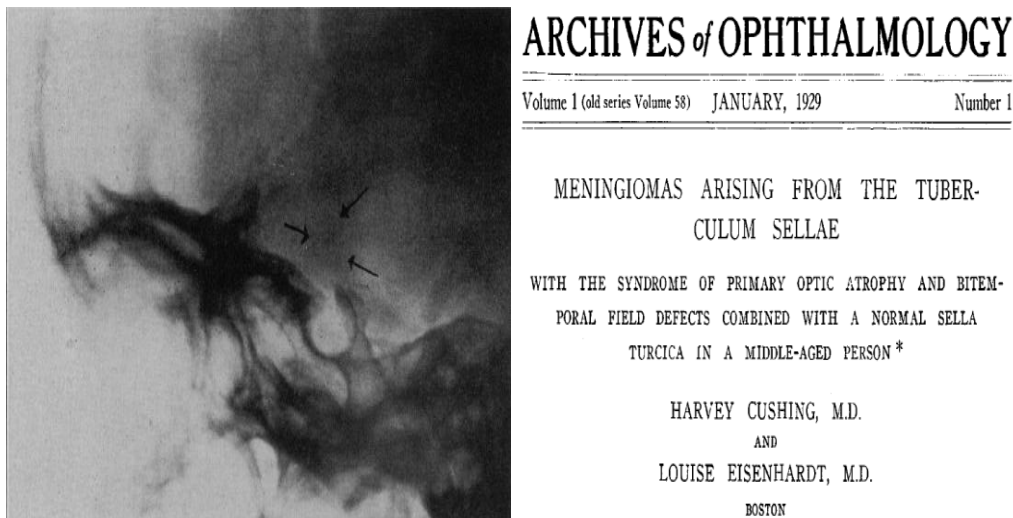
Plain x-ray skull from Cushing and Eisenhardt seminal study in 1929. Arrows are pointing to suprasellar shadow with normal appearing sella, which characterizes the chiasmal syndrome.¹⁰
